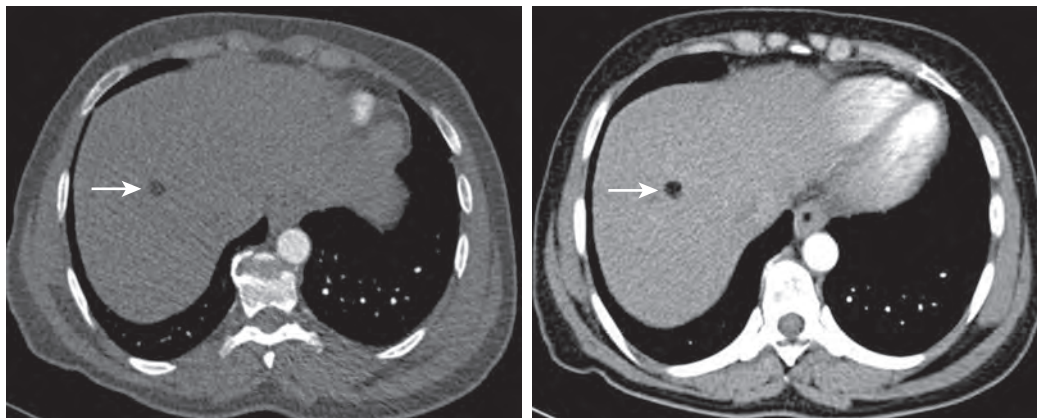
Lipoma: CT findings. A hepatic lipoma (arrows) that appears hypodense (fat density) on this contrast-enhanced scan.
